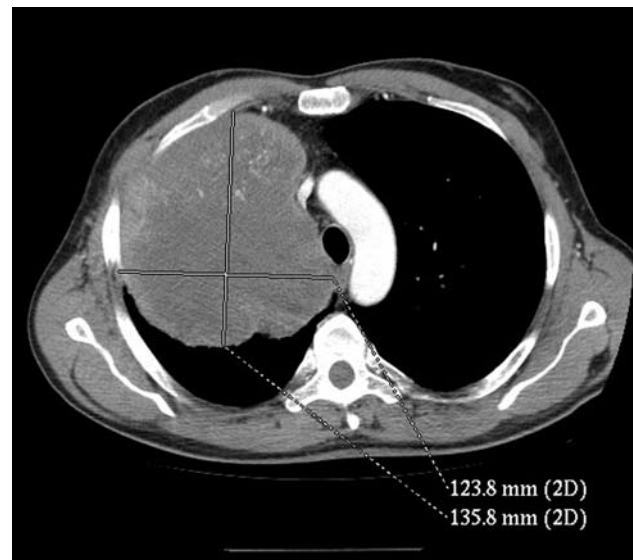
Tumor of the upper lobe of the right lung visible on CT-scan.
